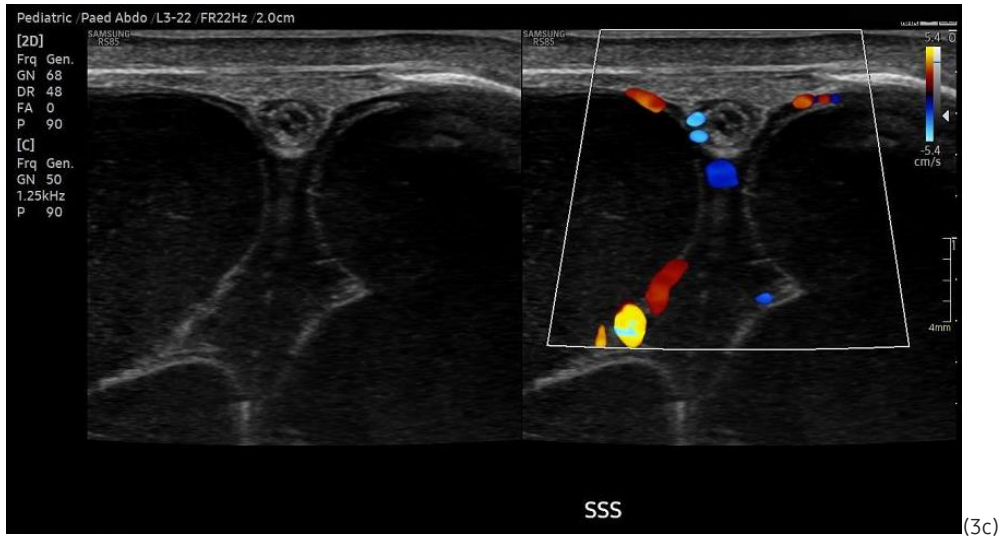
3c. Occlusive thrombus confirmed with L3-22 High Frequency probe on B-mode and colour Doppler within the superior sagittal sinus.
